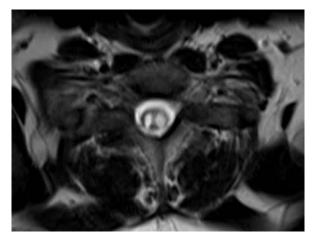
Cervical Spinal MRI showed a symmetrical, non-contrast-enhancing lesion which impacts on bilateral pyramidal tracts
